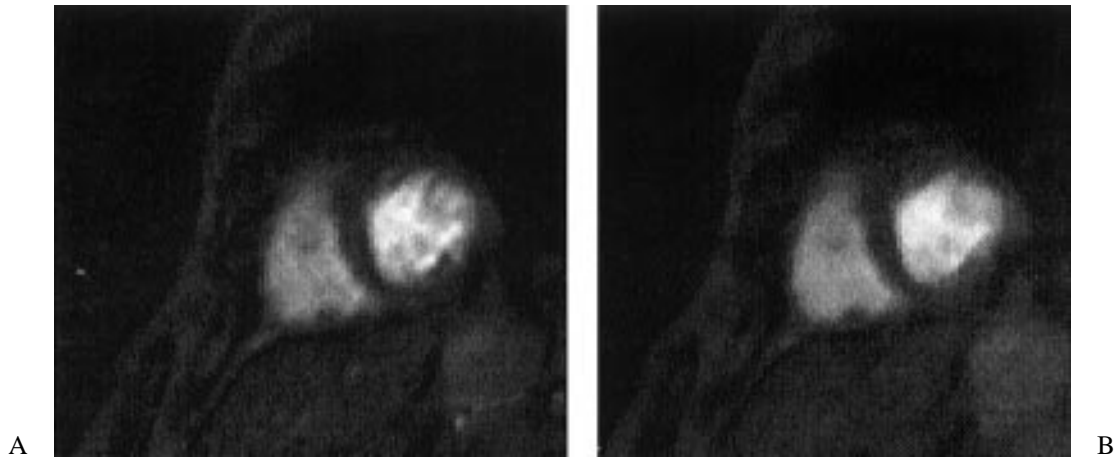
MR image of the middle of the heart of patient 1 at end-diastole (a). Smoothing of (A) with a median filter (B).
